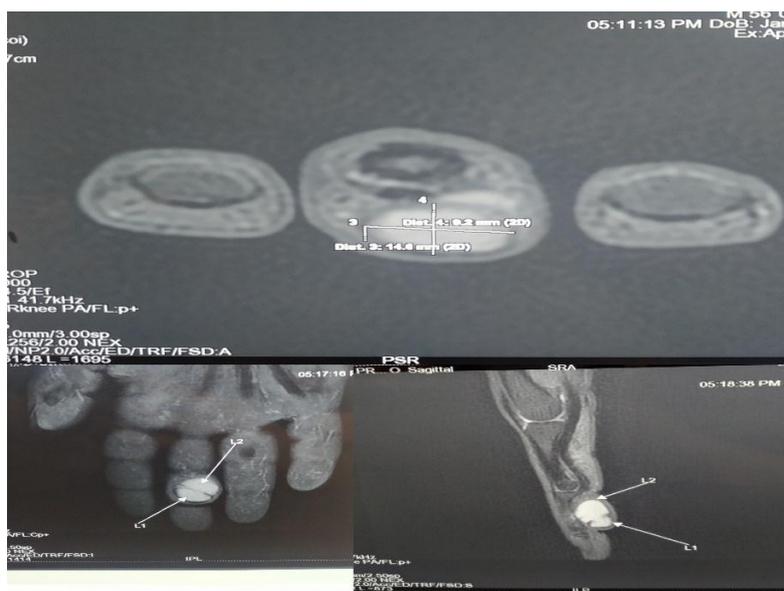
MRI of the hand showing the tumor in the flexor tendon sheath.
